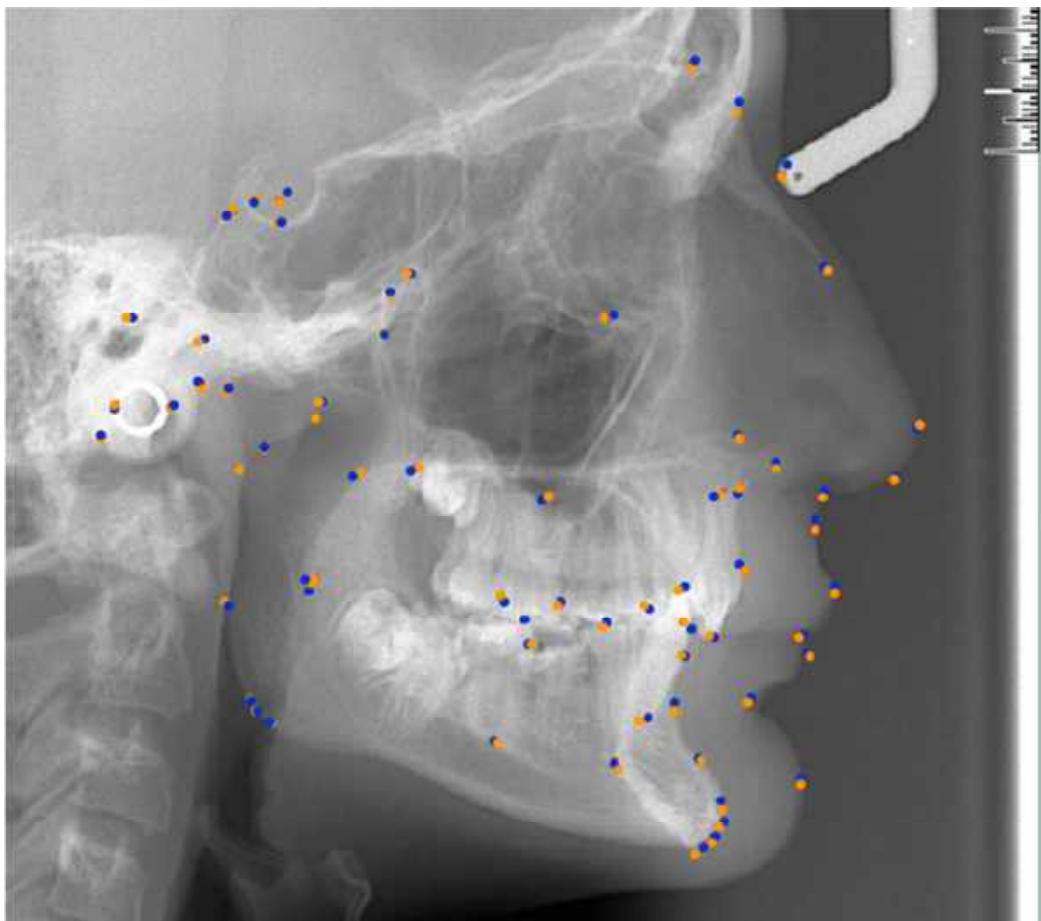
Example of a lateral cephalometric radiography with identification of landmarks by two observers.
